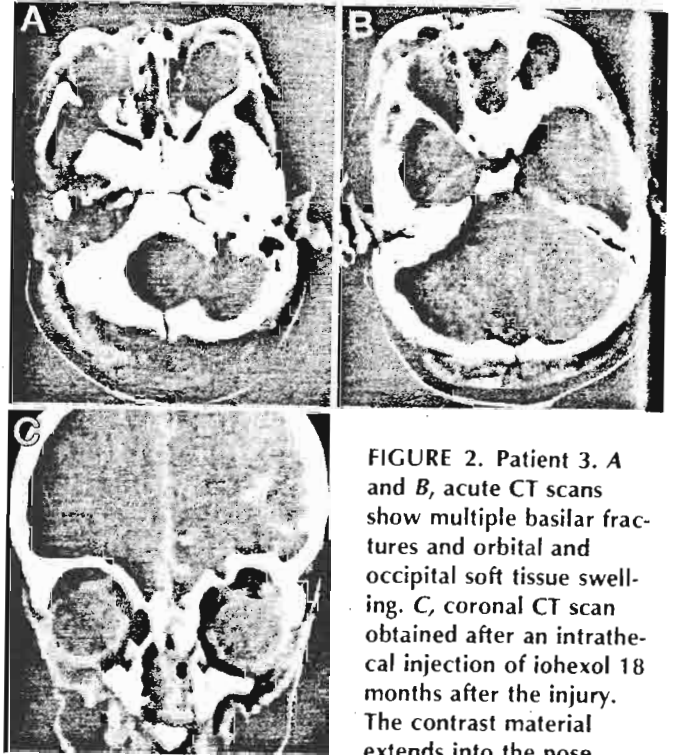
Patient 3. A and B, acute CT scans show multiple basilar fractures and orbital and occipital soft tissue swelling. C, coronal CT scan obtained after an intrathecal injection of iohexol 18 months after the injury. The contrast material extends into the nose through a defect in the left side of the ethmoid bone.
